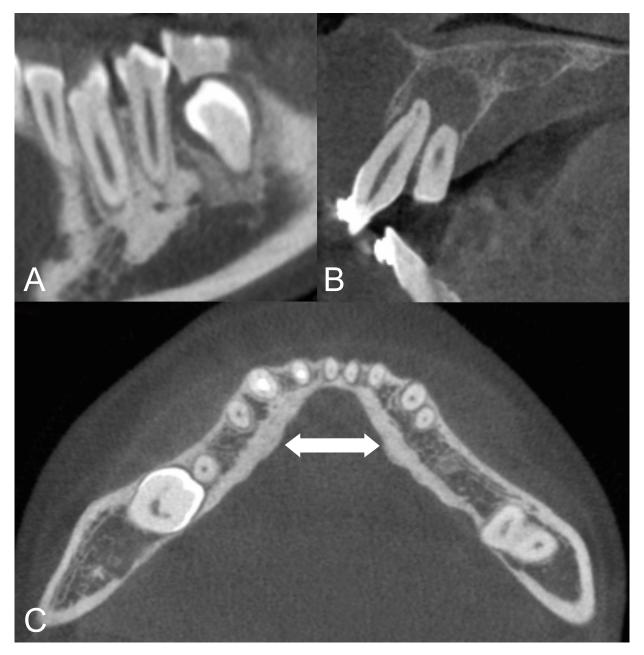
Representative cone beam computed tomography (CBCT) findings of bone structure and jaw lesions. (A) In the sagittal CBCT image; osteosclerosis is apparent in the area around teeth 33 and 34. (B) In the sagittal CBCT image, a radicular cyst is seen in tooth 21. (C) The axial CBCT image shows bilateral multiple mandibular torus.
